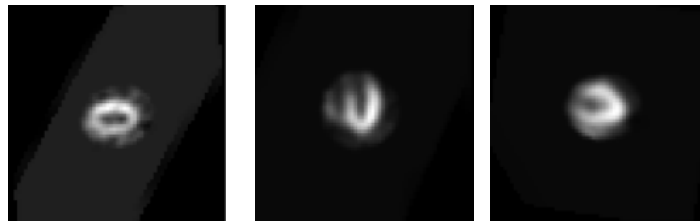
(a) From left to right, short axis, horizontal long axis and vertical long axis (adapted from [214]) and (b) correspondent myocardial perfusion SPECT slices, for perfusion analysis.
